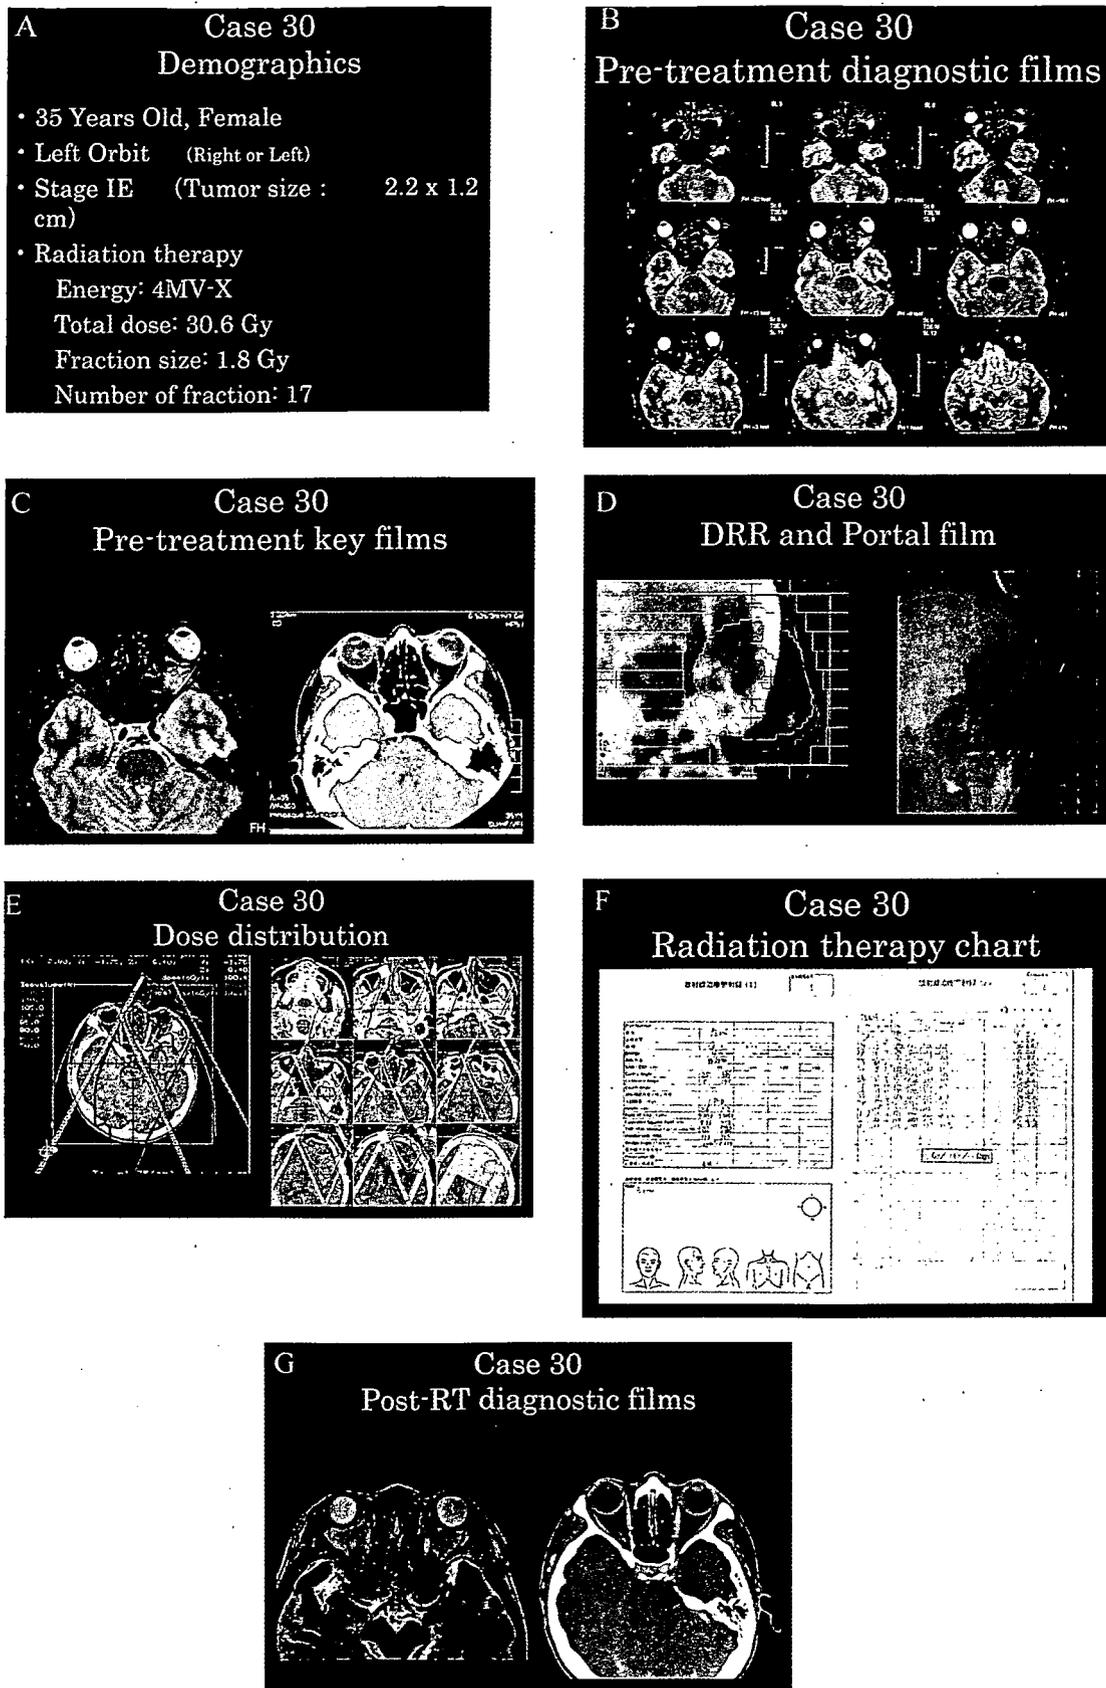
Examples are shown of the types of data that were used in this template. (A) a patient demographics, (B) pretreatment diagnostic films, (C) pretreatment key films, (D) digitally reconstructed radiograph (DRR) and portal film, (E) dose object, (F) radiation therapy chart, and (G) post treatment diagnostic films. The original documentation was written in Japanese. (Please note that a colour version of this figure is available as supplementary data at <http://www.jjco.oxfordjournals.org>)
